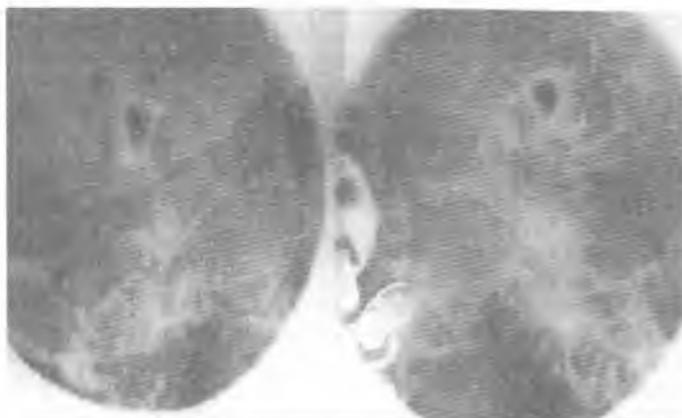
TMJ X-ray take in therapeutic position
